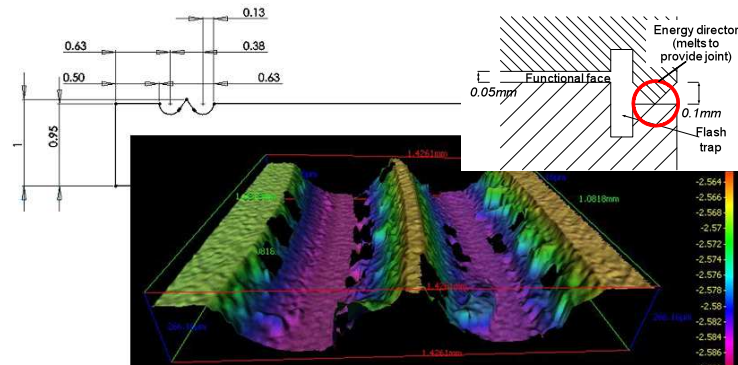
Design adaptation for ultrasonic bonding - energy director
